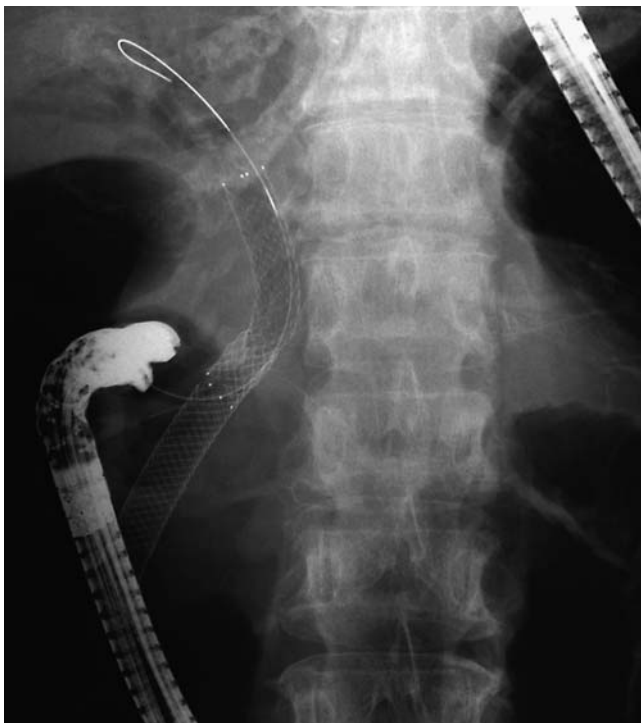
Radiograph showing placement of the uncovered self-expandable metallic stent in the stricture.
